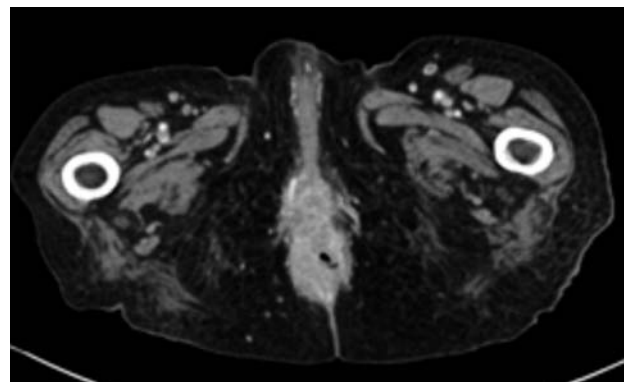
Abdominal CT-scan showing anal mass.
